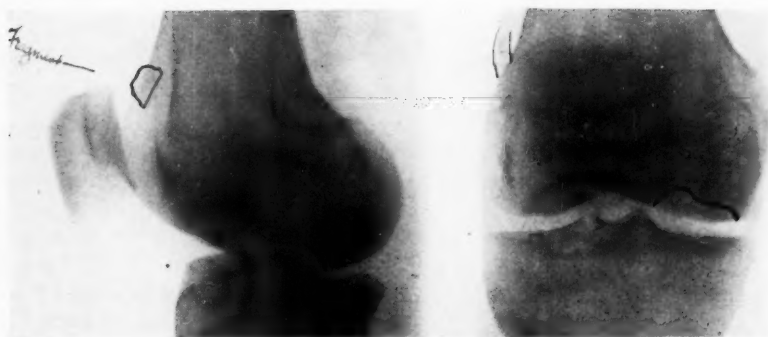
Lateral and anteroposterior X-ray views, showing area of fracture.
